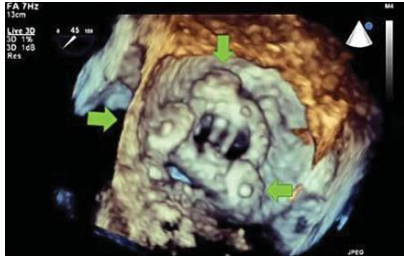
Three-dimensional transesophageal echocardiography image shows a mitral annular calcification (arrow) and a mitral annular dissection (arrowhead).
